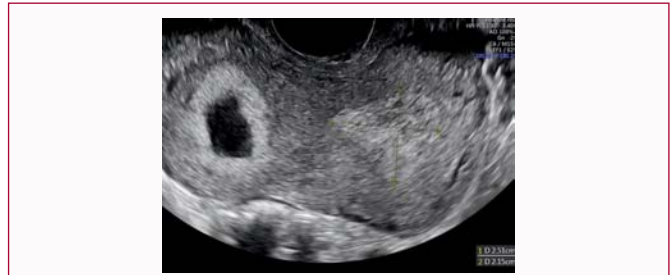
Transvaginal ultrasound image showing location of gestational sac at 7 weeks 5 days in the right uterine cornua with dense decidua in the left uterine cavity.
